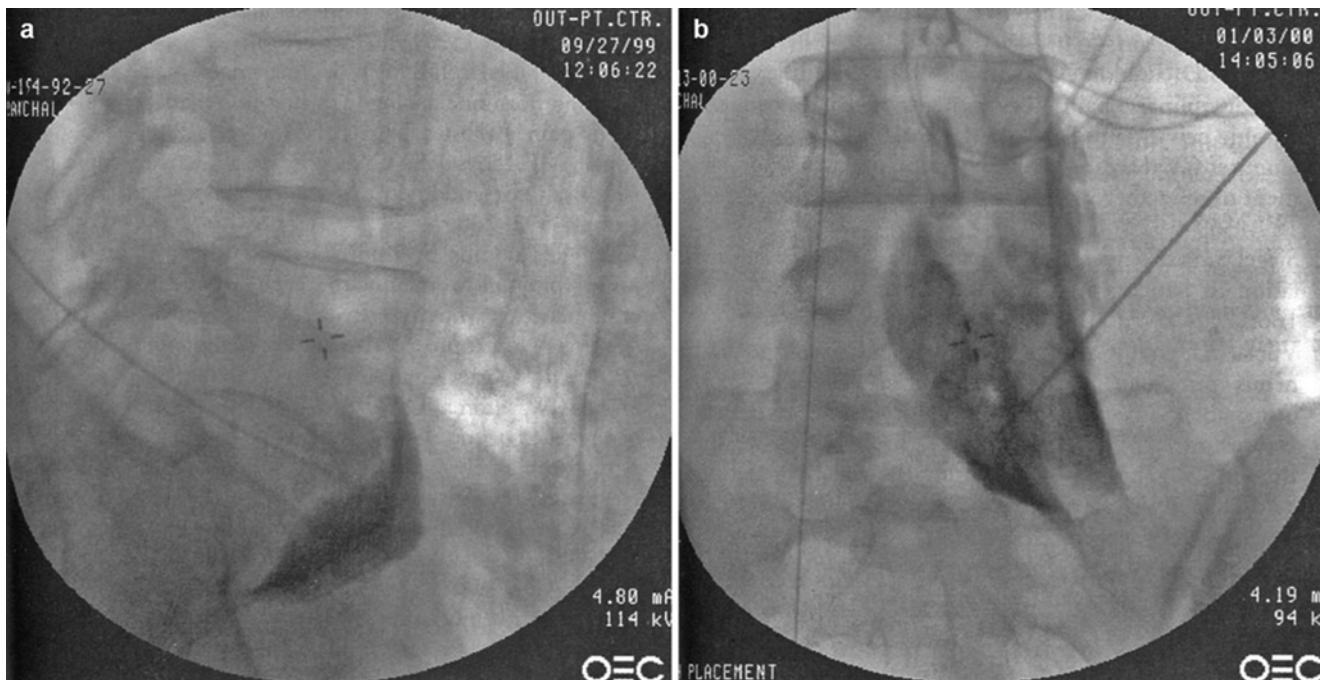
(a) The radiographic lateral view shows the needle placed at the superior hypogastric plexus. (b) This image shows correct needle placement from the contralateral side. (Raj Interventional Pain Management Image-Guided Procedures)
